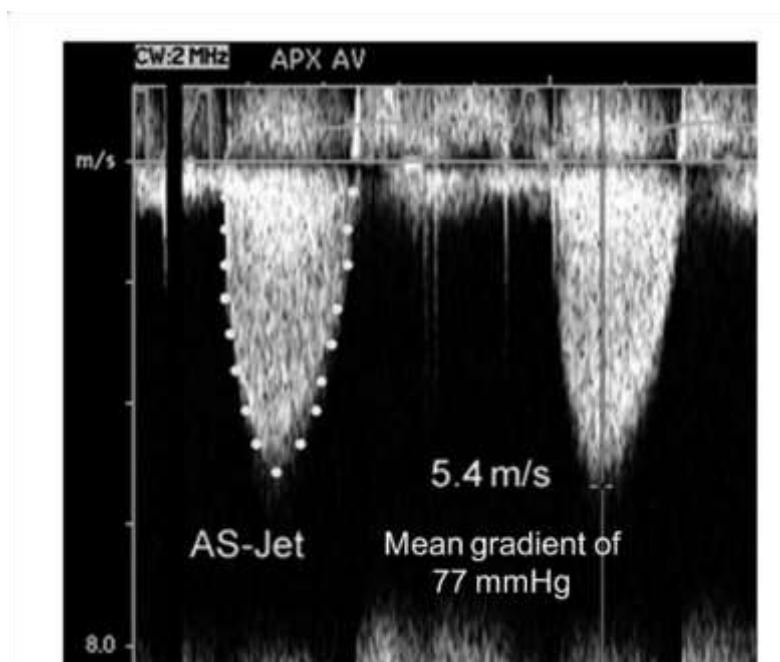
Continuous wave spectral Doppler, showing the peak velocity and the points where measurements could be taken for the pressure gradient.
